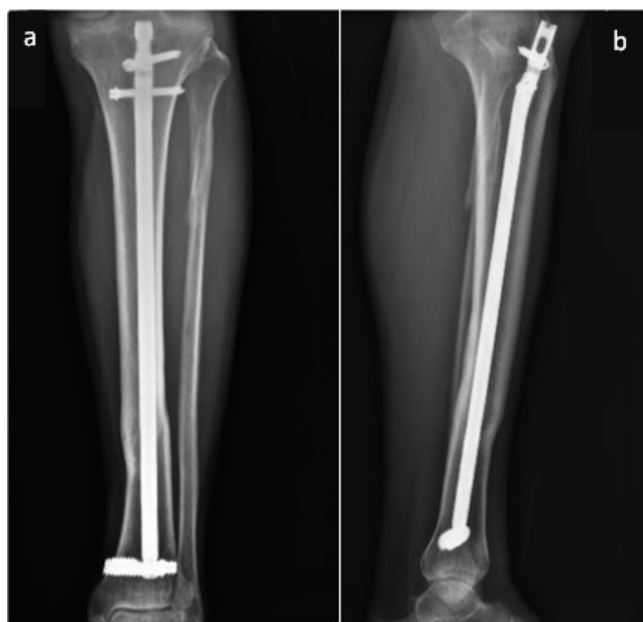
X-ray images of a patient treated with DSBLs at 43 months postoperatively a: AP view b: LAT view
